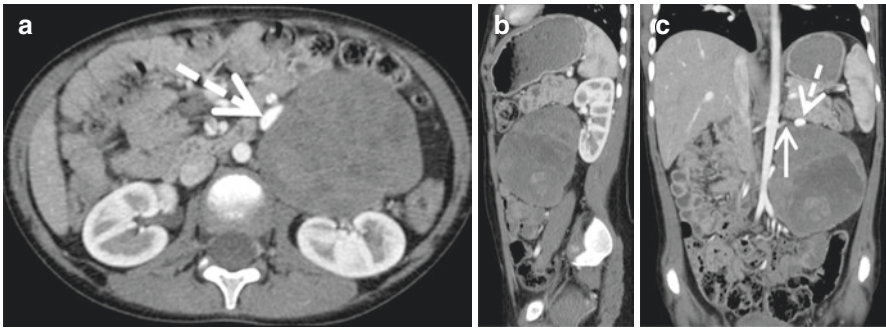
A 4-year-old girl with localized prerenal neuroblastoma (MYCN non-amplified, segmental chromosome alterations, INSS stage 3, INRGSS L2). Contrast-enhanced transverse CT scan (a), sagittal (b) and coronal (c) views. The tumour demonstrates moderate and heterogeneous enhancement. The tumour arises from the periarterial sympathetic fibres. It displaces upwards and forward the left renal pedicles (artery, arrow; vein, dotted arrow)
